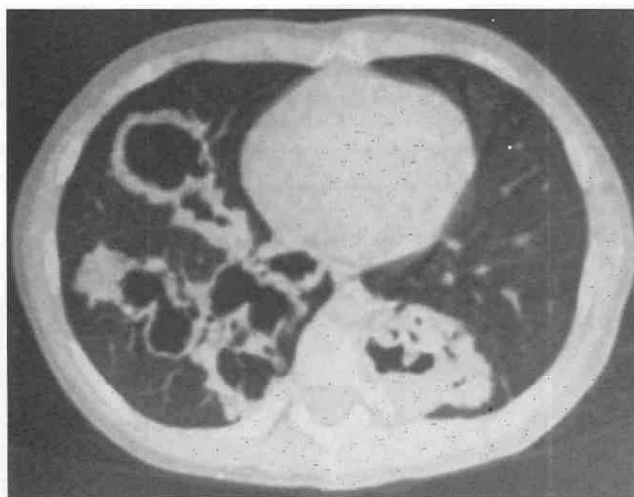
Advanced tracheolaryngeal papillomatosis. CT shows extensive cavitary spaces that have a branching and clustered appearance reminiscent of cystic bronchiectasis. The walls are thick and irregular. (From Kuhlman JE, Reyes BL, Hruban RH, et al: Abnormal air-filled spaces in the lung. *Radiographics* 13:47-75, 1993.)
